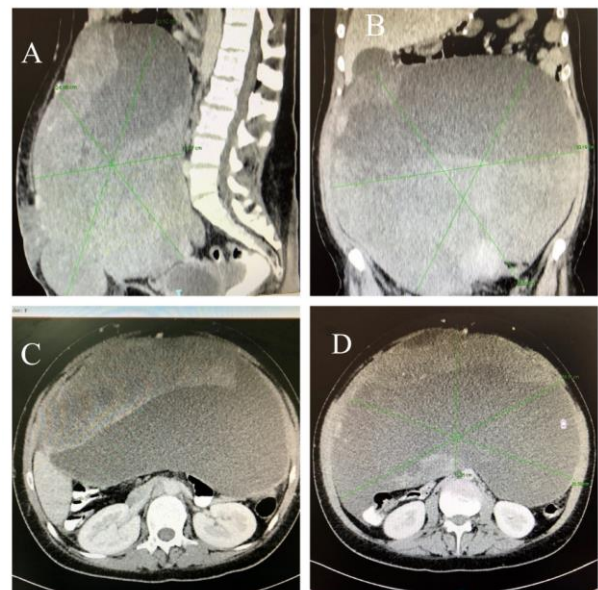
Computed tomography (CT) scans: sagittal (A), frontal (B), axial (C, D) showed a heterogeneous tumor formation, occupying a large part of the abdominal cavity, with displacement of intestinal loops and internal organs laterally and upward.
